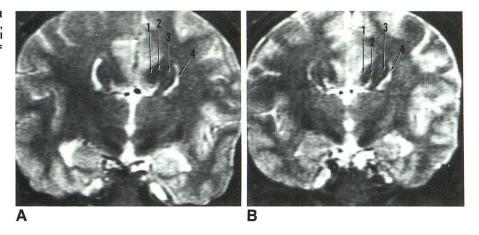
A and B, Coronal T2-weighted MR images of twin 1 (A) and twin 2 (B). 1 = enlarged, rotated cingulate gyrus; 2 = CSF-filled lateral callosal cistern; 3 = Probst callosal bundle; 4 = concave frontal horn.
